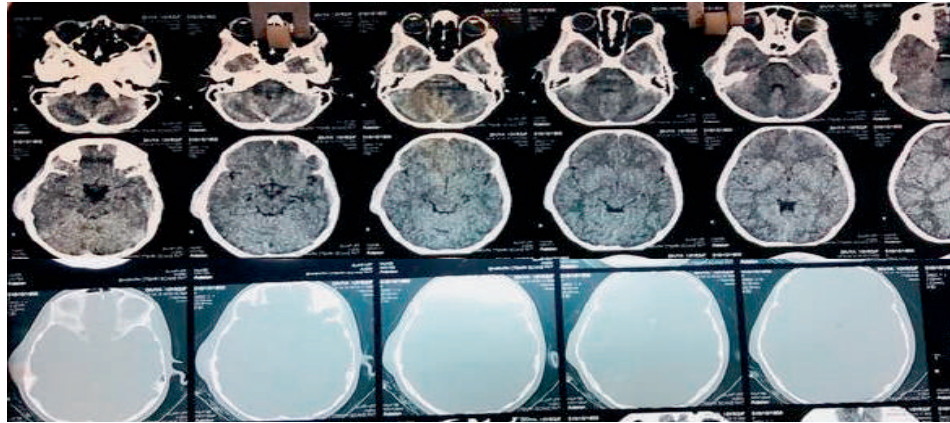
CT Scan - right temporal extracranial lesion
